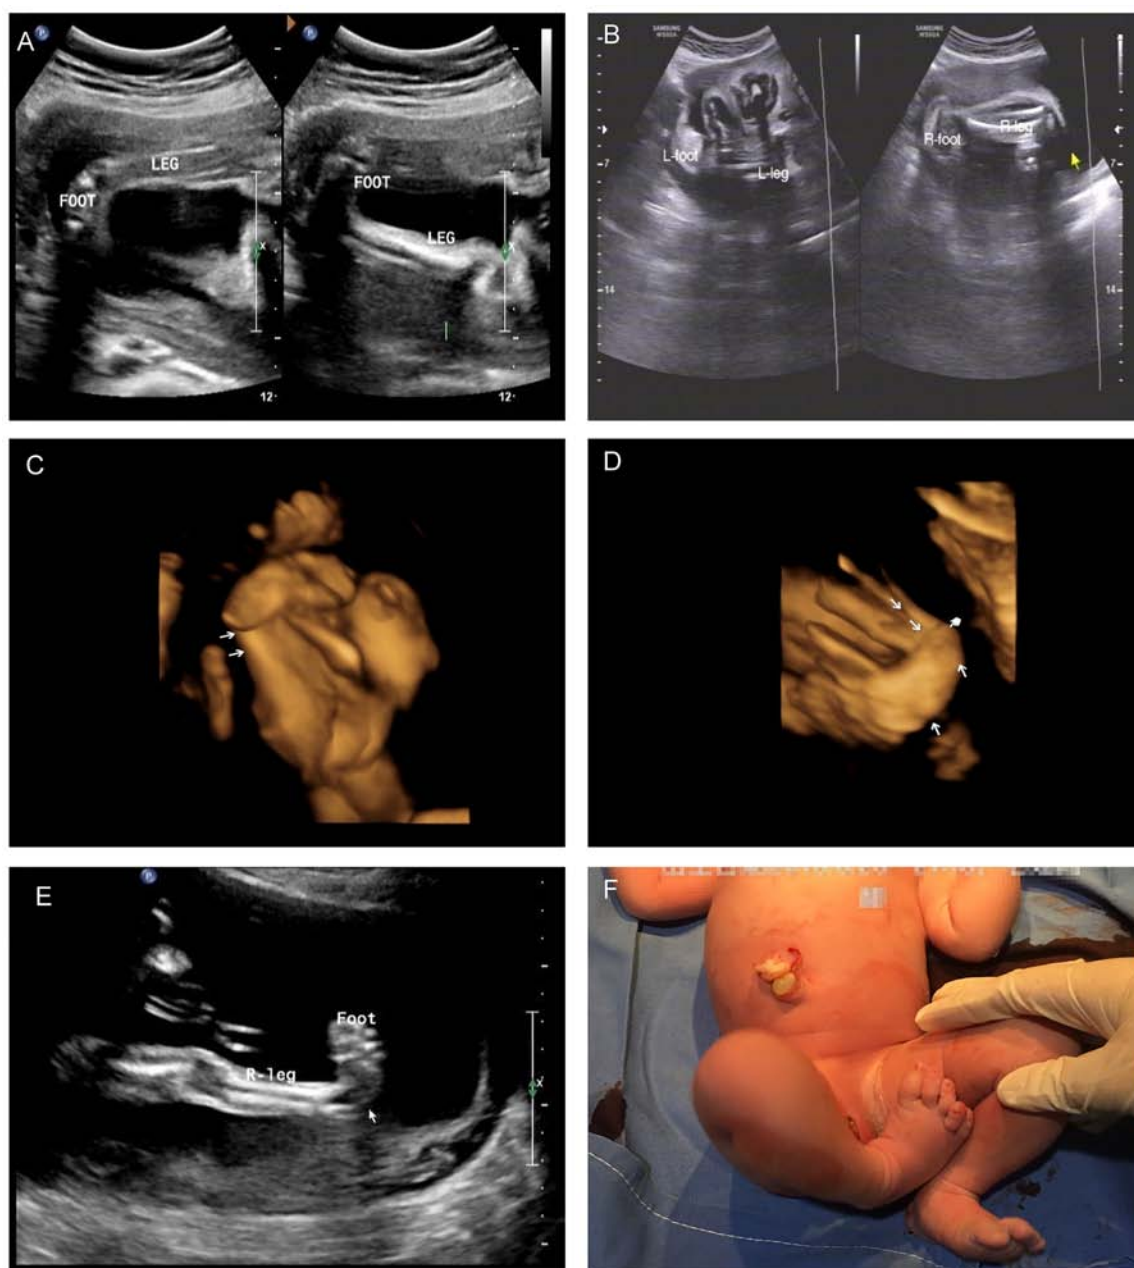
Representative clinical and ultrasonic images of the recruited subjects. (A) Case 1: Bilateral CTEV at 22 gestational weeks. (B) Case 2: Bilateral CTEV at 20 weeks. View (C) 1 and (D) 2 of case 3: Bilateral CTEV at 21 weeks. (E) Case 8: Unilateral (right) CTEV at 23 weeks. (F) Case 9: Unilateral (right) CTEV at birth. Arrows indicate the affected parts. CTEV, congenital talipes equinovarus.
